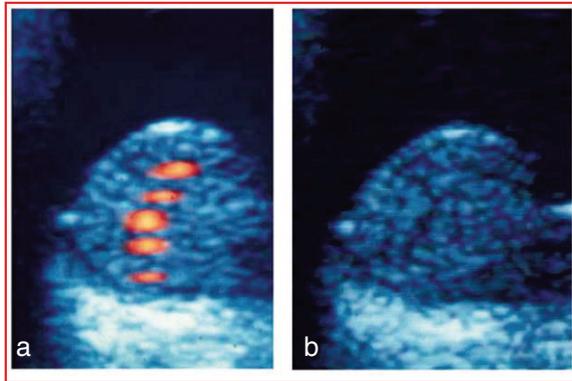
a) Using highest sensitivity of the amplifier and decreasing the wall filter setting, we can differentiate between a structure of red color coding (vessels with the flow toward the transducer) and a circumscribed area close to the peak of the melanoma in which the blood flows away from the transducer (blue). This type of sonography may give us new clues as to planning and controlling the treatment of intraocular tumours. b) Color-coded Doppler signal analysis shows that this area is the origin of frequency shifts toward the transducer.
